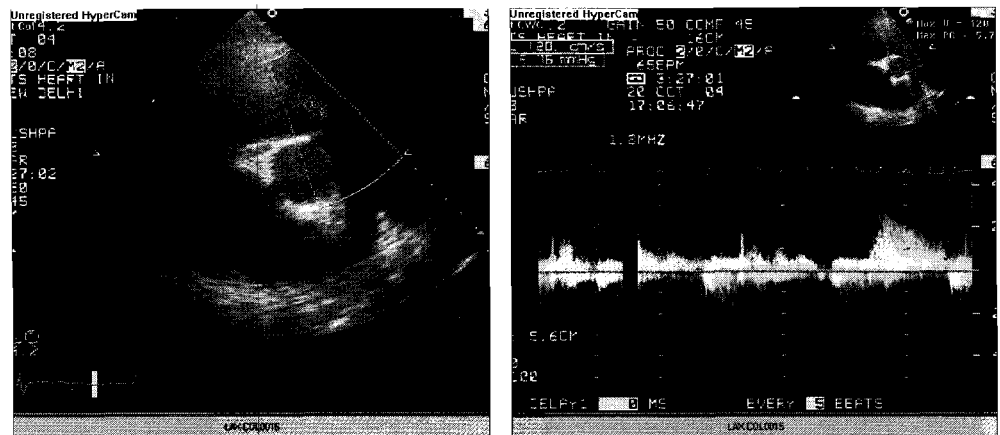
Continuous wave Doppler across pulmonary valve in patient with PR showing peak velocity. It is useful in PADP estimation (see text)
